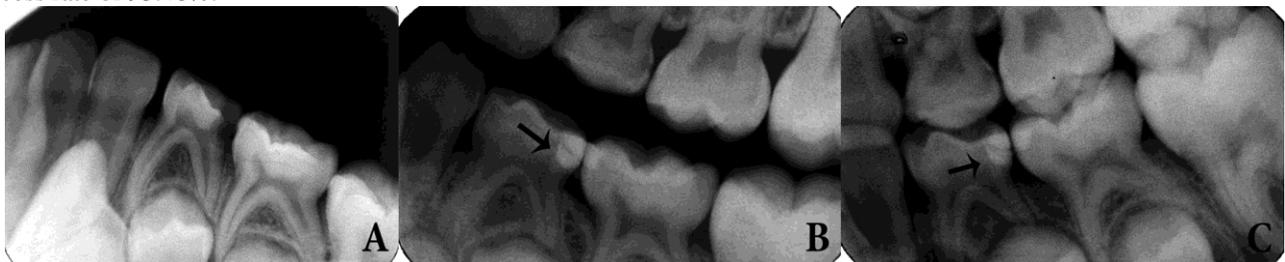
G.St. 4 year old boy. A. Radiograph taken before treatment showing deep carious lesion (teeth 54) and normal periapical conditions. B: Six months after direct pulp treatment using MTA.No visible calcified tissue formation (arrow). C. 12 months after DPC. Review showing normal furcation radiolucencies. No calcified tissue formation
